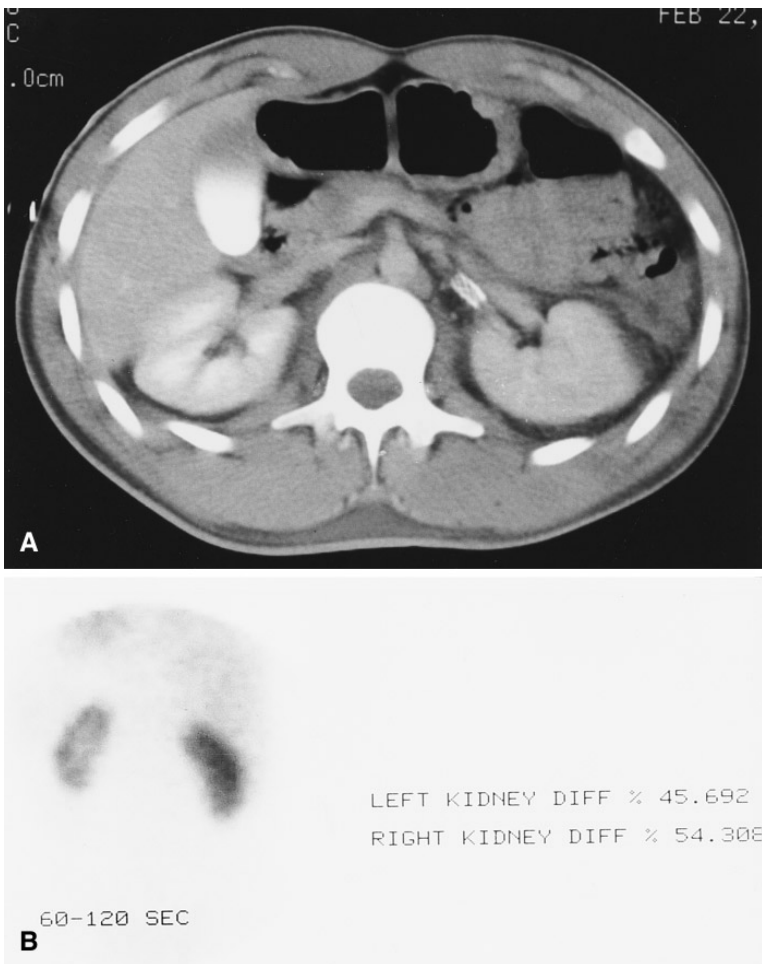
A Contrast-enhanced CT scan of the abdomen post-stent placement demonstrates the Palmaz stent in situ in the left renal artery and improved perfusion to the left kidney. B A nucleide scan 9 months following stent insertion shows no significant differential uptake between right and left kidneys.
